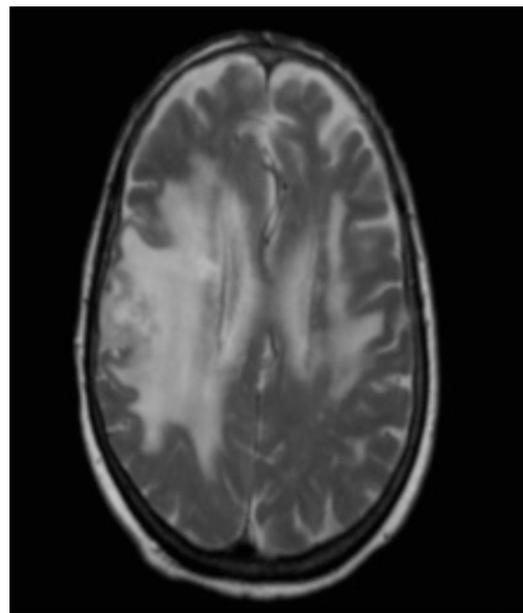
Brain MRI T2-weighted sequence. Hyperintense lesions on the right temporoparietal area and the left temporal area with associated vasogenic oedema.
